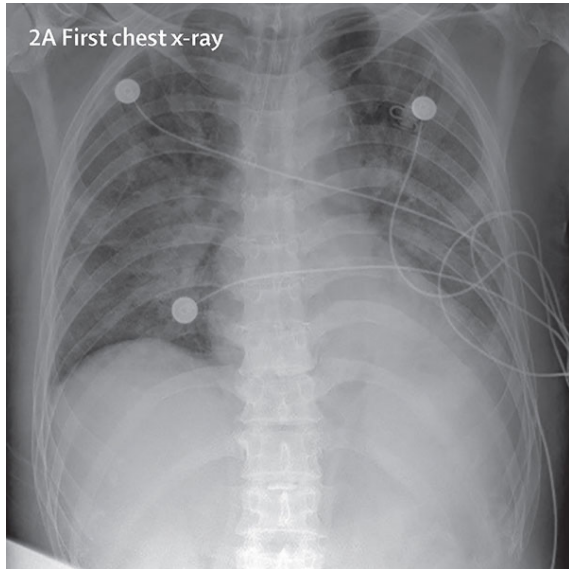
Example of an X-ray image taken from a patient with a positive test for COVID-19. Using X-ray images, we can train a machine learning classifier to detect COVID-19 using Keras and TensorFlow.
